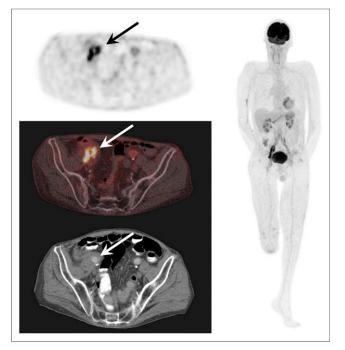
¹⁸F-FDG PET/CT images in combination with contrastenhanced CT images (lower left) of 75-y-old man with medical history of chronic obstructive pulmonary disease, right femoropopliteal bypass, and aortobifemoral bypass who was admitted because of fever. Blood cultures were positive for methicillin-susceptible *S. aureus.* Transesophageal echocardiography was negative for endocarditis. ¹⁸F-FDG PET/ CT showed infected right iliac vascular prosthesis. This patient was treated with antibiotic therapy for 5 mo, and because of extensive infection he finally underwent vascular surgery.
